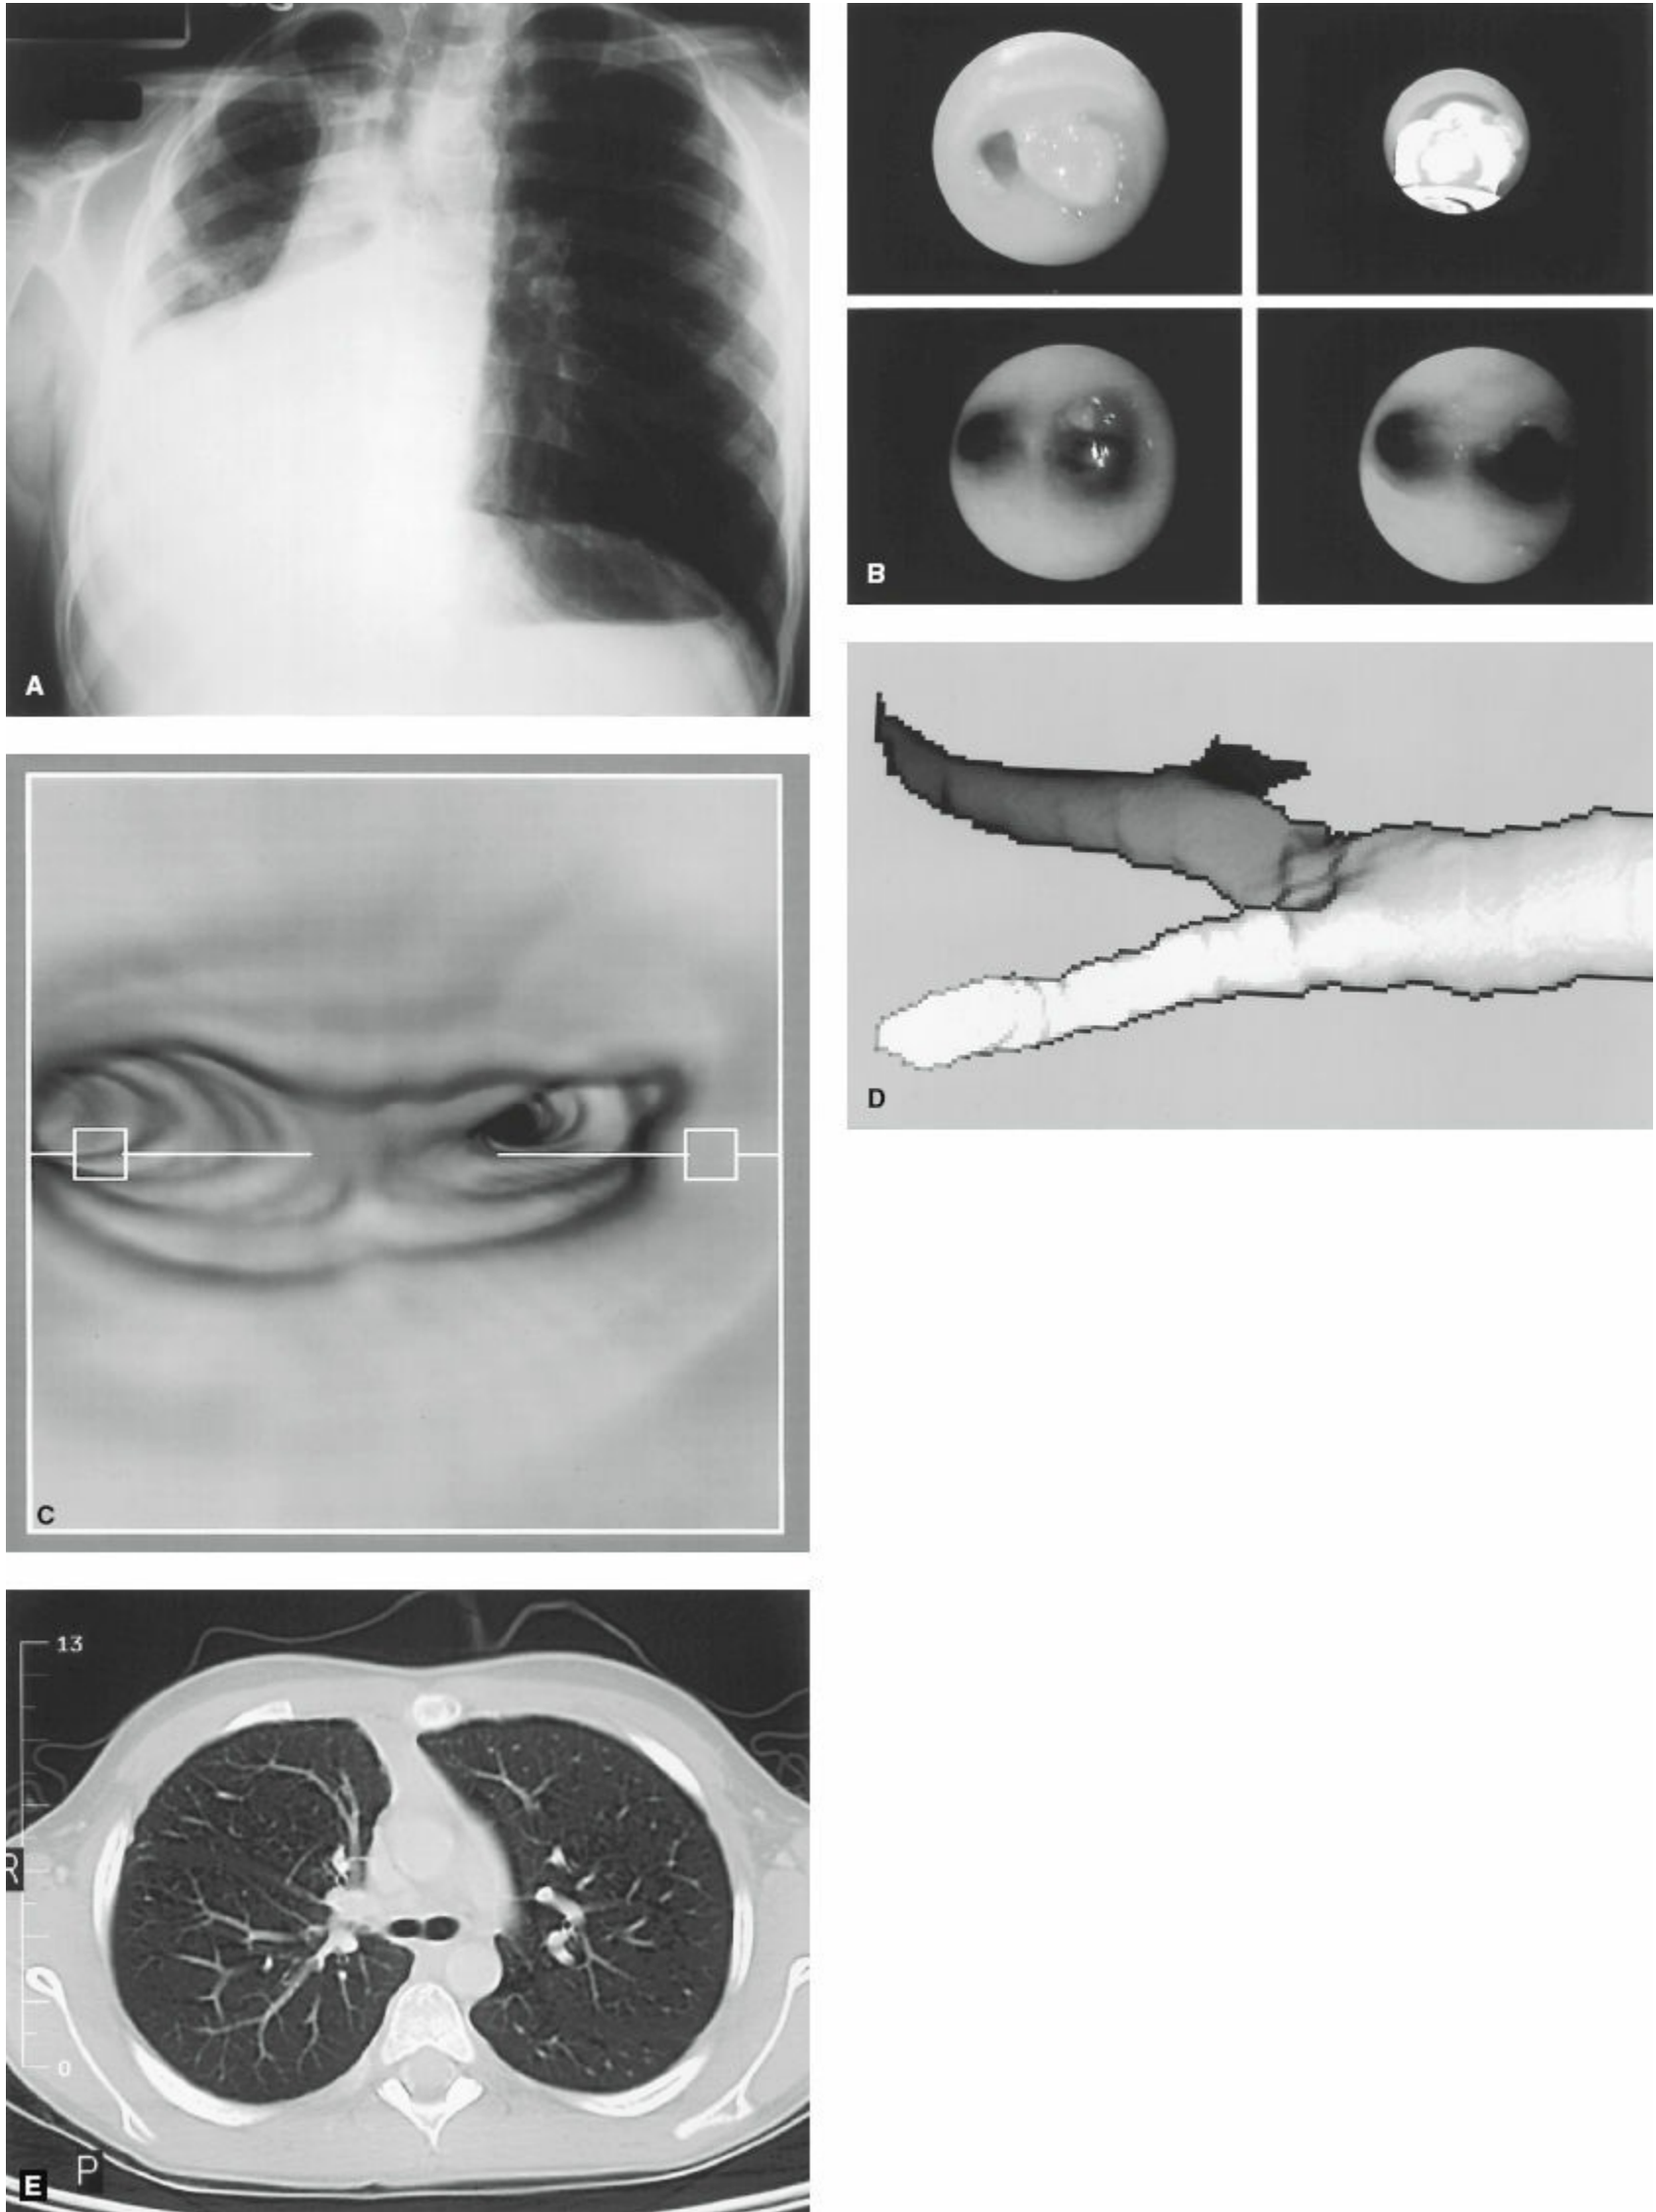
Lung neoplasm in an 8-year-old child: inflammatory pseudotumor. A: Presenting chest radiograph with right lung collapse. B: Biopsy of an obstructing endobronchial mass demonstrates inflammatory pseudotumor (inflammatory myofibroblastic tumor). C: Computerized tomographic “virtual bronchoscopy” image after initial biopsy demonstrates deformation of the right main stem bronchus and carina due to tumor infiltration. D: Computerized tomography reconstruction of the external appearance of airways demonstrating the deformation of the carina and right main stem bronchus. The child underwent excision of the right main stem bronchus and carina and tracheobronchial reconstruction. E: Postoperative transverse thoracic computerized tomography at the level of the reconstruction of the carina.
